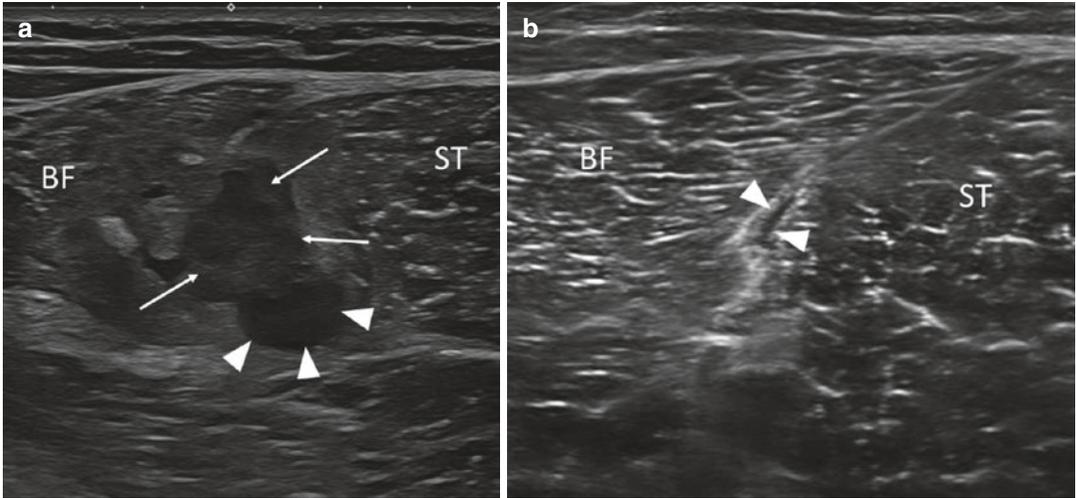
(a) Severe injury of the common tendon of the hamstrings. Transverse ultrasound of the left posterior thigh shows hypoechoic disruption (arrows) with hematoma (arrowheads) in the common tendon. (b) Small injury of the common tendon of the hamstrings. Although
